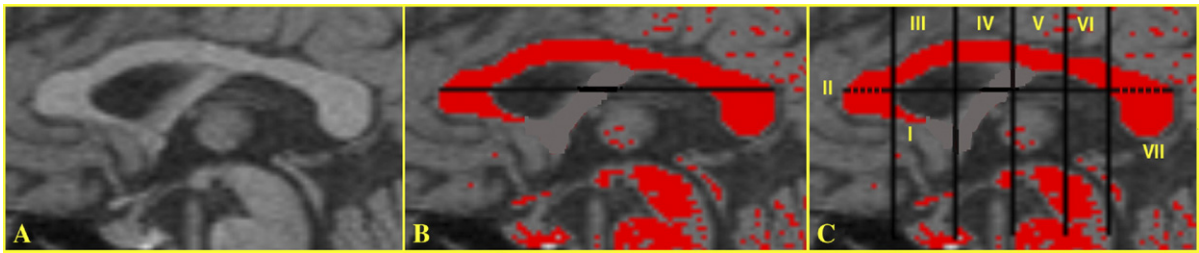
Semi-automated morphometric analysis of the corpus callosum. 2A — Mid-sagittal MR image of the corpus callosum with clearly visible cerebral aqueduct. 2B — Corpus callosum segmentation with the black line connecting the most anterior CC pixel with the most posterior CC pixel through the point of maximum curvature of the inner border of the genu. 2C — Corpus callosum divided into various subdivisions semi-automatically by the software. The subdivisions divided by dotted black line on the anterior aspect of the corpus callosum (left side) were added to measure the genu and that on the posterior aspect of the corpus callosum (right side) were added to measure the splenium.
